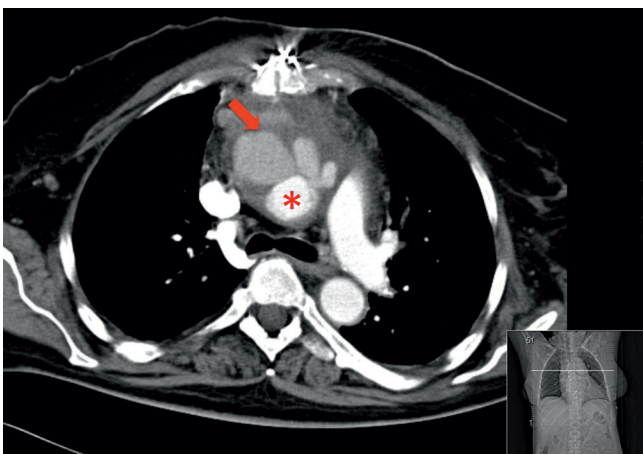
Preoperative computed tomography. (Red asterisk) Ascending aortic prosthesis. (Red arrow) Infected aortic prosthesis pseudoaneurysm with adjacent hematoma.
